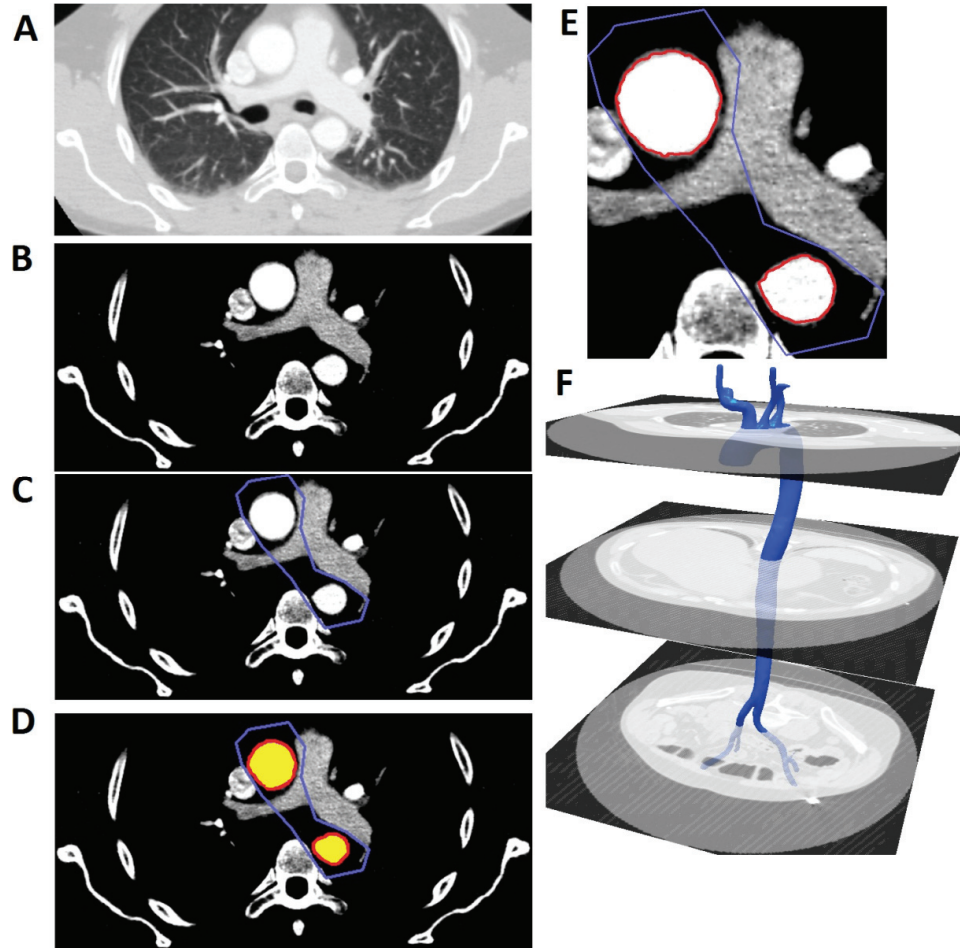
(A) A typical CT image sampled from data provided by South Karelia Central Hospital. The image processing operations of (B) contrast adjustment, (C) Selection of ROI, (D) image segmentations (area in yellow is segmented as artery lumen), (E) artery lumen contour generation, and (F) 3D surface rendering performed with medical image processing code 3D-Doctor.
